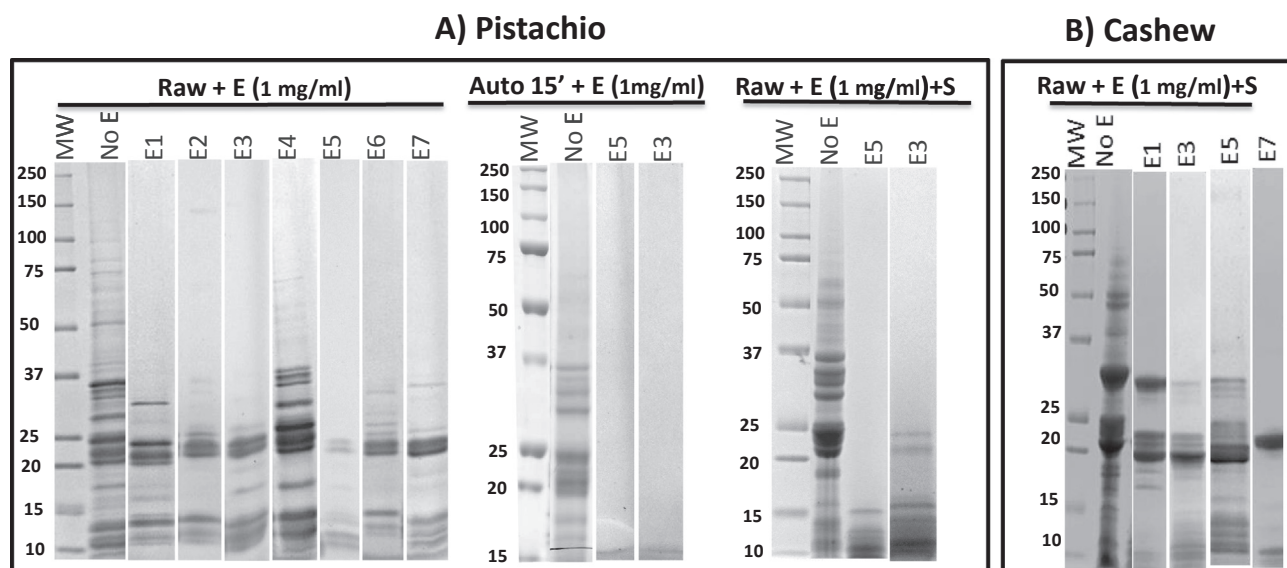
A) SDS-PAGE analysis of the ability of various enzymes to digest pistachio proteins. Seven enzymes (E1–E7) were used at 1 mg/ml concentration to digest pistachio BSB extracts untreated (Raw, left panel) during 19 h without ultrasound treatment. Middle panel: Autoclaved pistachio BSB extract (120 kPa, 15 min) digested with enzymes E3 and E5 during 19 h without ultrasound treatment. Right panel: Digestion experiments of whole pistachio paste with enzymes E3 and E5 subjected to 1 h of ultrasound treatment (S). B) SDS-PAGE of digestion experiments of whole cashew paste with enzymes E1, E3, E5 and E7 subjected to 2 h of ultrasound treatment (S) Molecular weight marker (MW) and undigested pistachio or cashew (No E) are also shown. Each lane was loaded with 20 µg of protein. 4–20% Tris-glycine gels were used.
